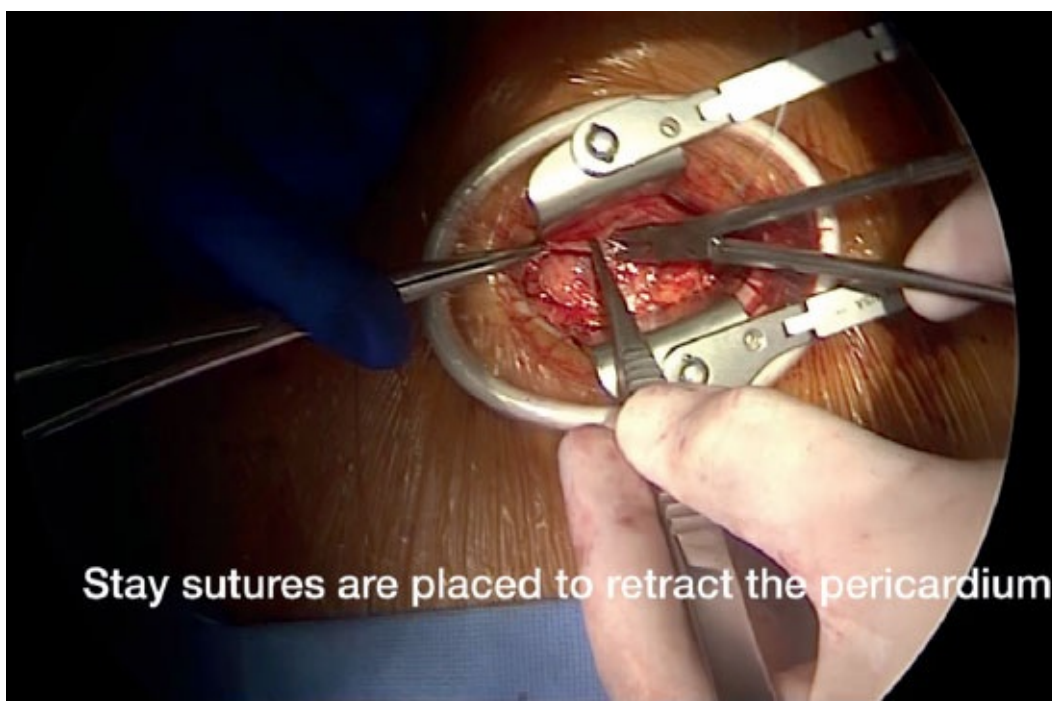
The apex of the LV can be approached via a left anterolateral minithoracotomy. The best intercostal space level to approach the apex can be variable. The preoperative CT scan can be used for measurements and identification of external landmarks to enter the appropriate interspace, usually the fifth or sixth left interspace. Fluoroscopy can also be used with a hemostat clamp to mark the level of the apex. A 5-cm incision is made below the left mammary fold medial to the nipple.
